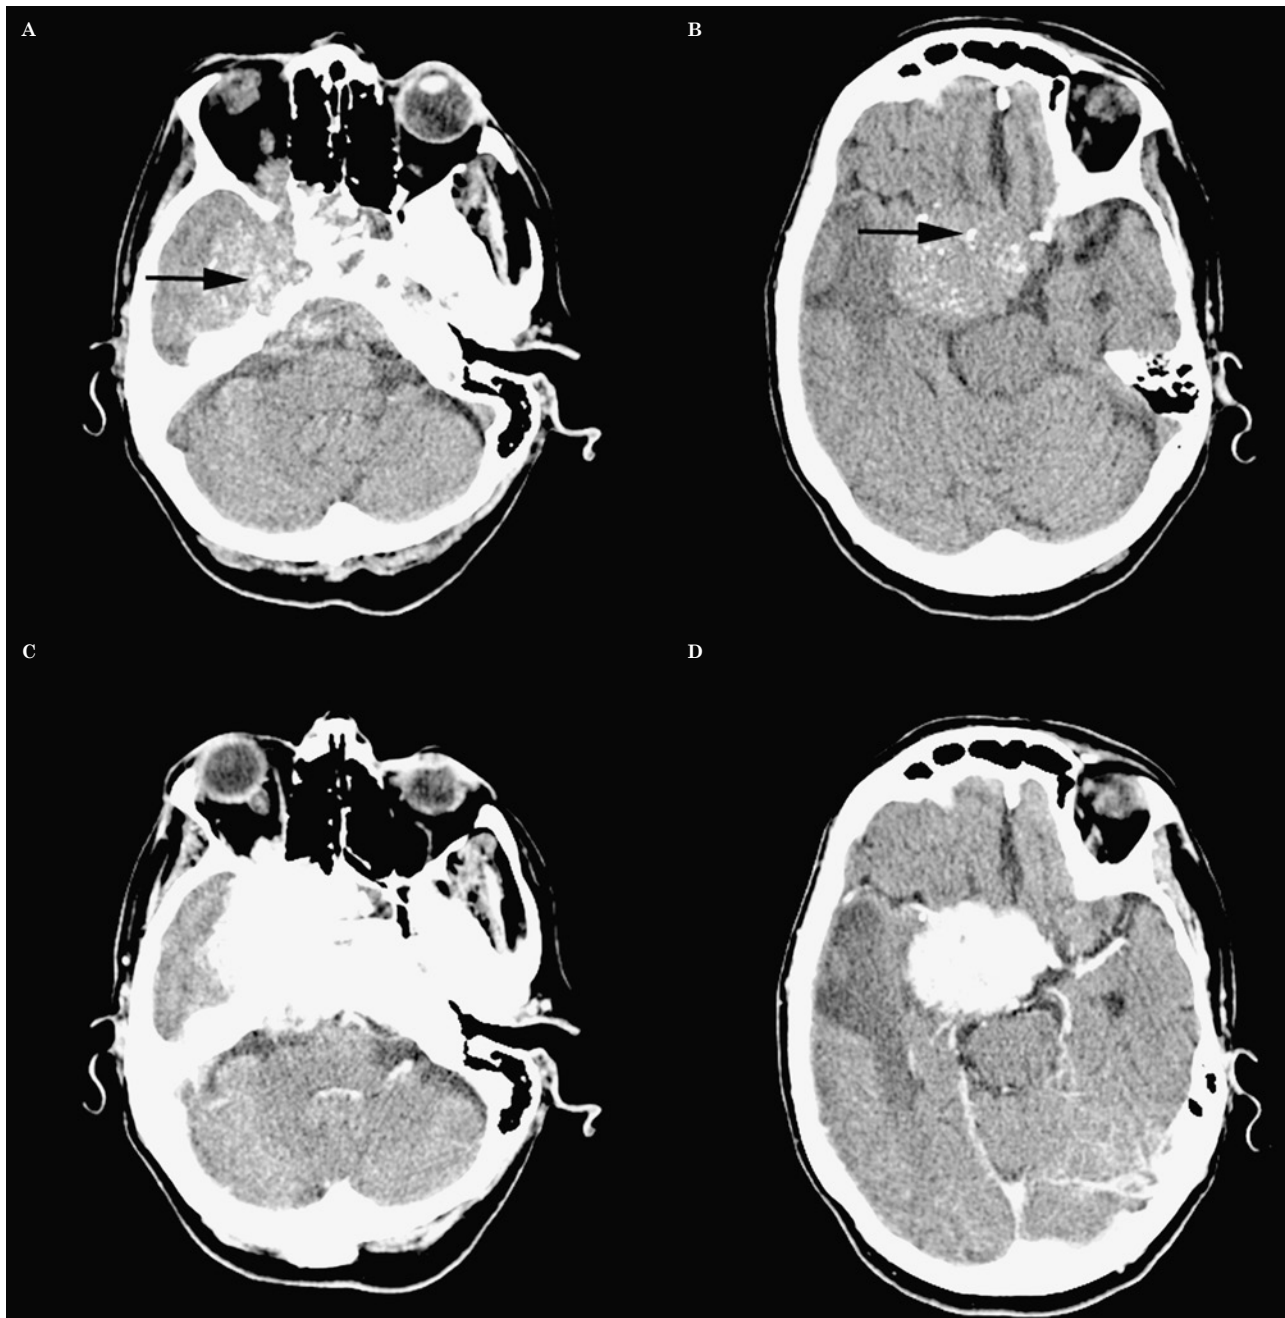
Meningioma. Noncontrast CT (A,B) reveals a large hyperdense lesion arising from the right sphenoid wing and extending into the suprasellar cistern. The mass contains coarse calcifications (arrows) and causes vasogenic oedema in the right temporal lobe. Avid enhancement is noted on the post-contrast images (C,D).
